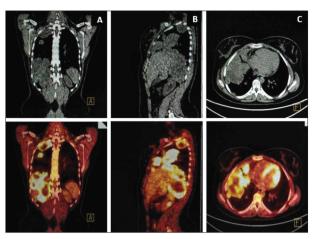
A – coronal; B – sagittal; C – axial computed tomography, fused positron emission tomography/computed tomography images (mediastinal window) of multiple single and fused nodular and soft tissue changes of variable size in the middle and lower lobe of the right lung, partly continuously with the mediastinal, costal and diaphragmatic pleura, which bind ¹⁸F-fluorodeoxyglucose inhomogeneous intensely, with zones of absent ¹⁸F-fluorodeoxyglucose accumulation corresponding to zones of necrosis or hemorrhage
